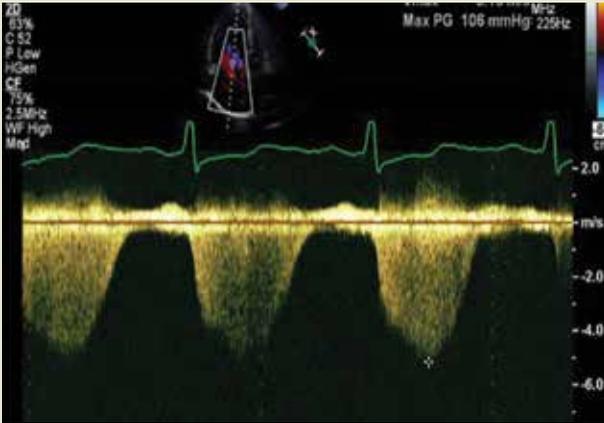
Echocardiography – continuous wave Doppler interrogation of the tricuspid regurgitation jet. A markedly elevated peak velocity of 5.2 m/s is shown, with a corresponding right ventricular to right atrial pressure gradient of 106 mmHg. This patient has severe idiopathic PAH with elevated pulmonary artery pressure to systemic levels found at right heart catheterisation.
